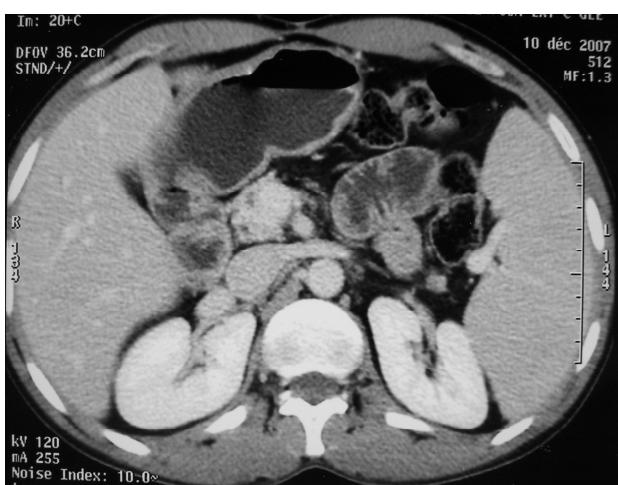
CT control after a six-month anti-tuberculosis therapy: partial resolution of the mass.
